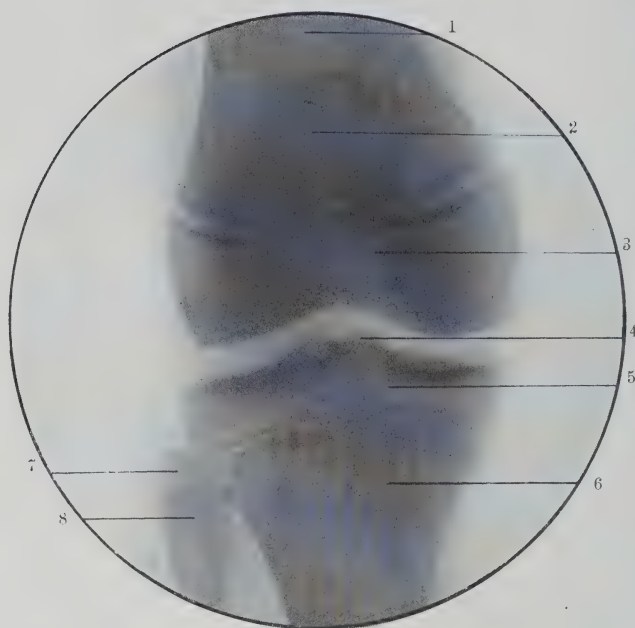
Radiograph Showing Vertical View of Knee at Eleven Years. 1, Femur; 2, patella; 3, lower epiphysis of femur; 4, spine of tibia; 5, upper epiphysis of tibia; 6, tibia; 7, upper epiphysis of fibula; 8, fibula. (Original.)
